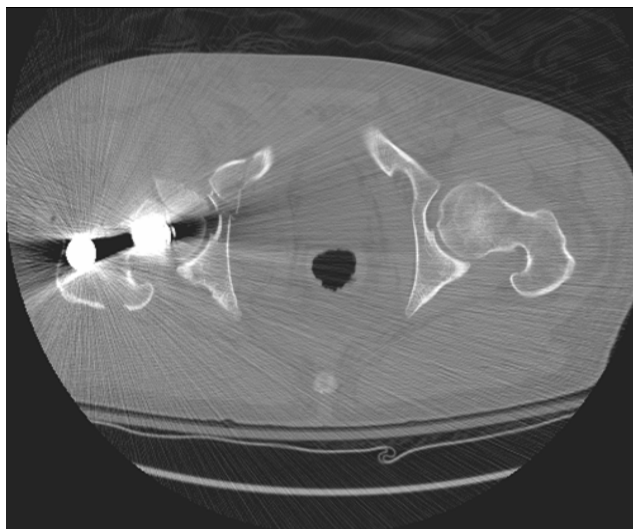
Computed tomography scan shows the right femoral head fracture flipped 180° in the acetabulum.
